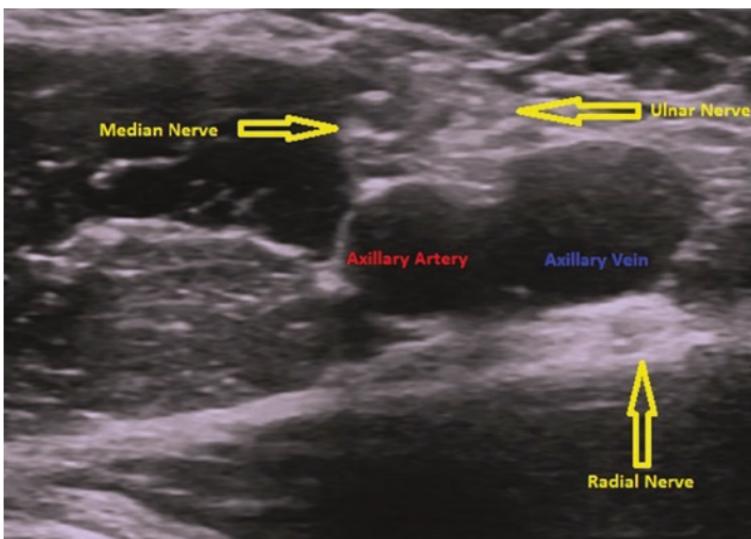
Ultrasound image of Axillary brachial plexus block
